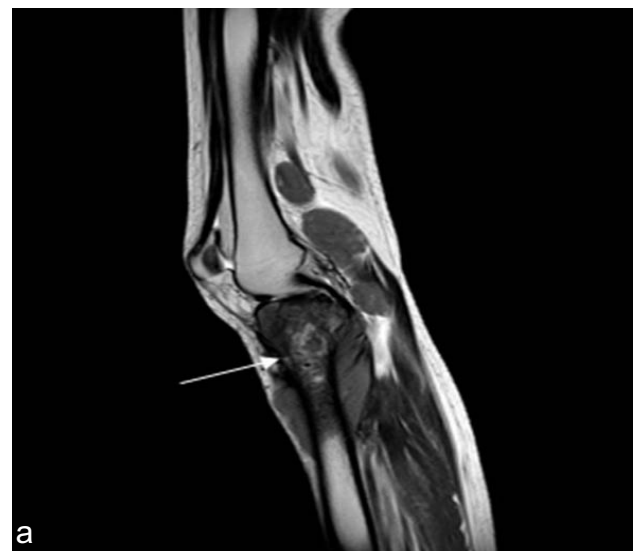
(a,b): MRI with contrast T2w showing heterogeneously enhancing marrow lesion involving upper left tibia (case of DLBCL) and having tumor extension into the adjacent soft tissue.
